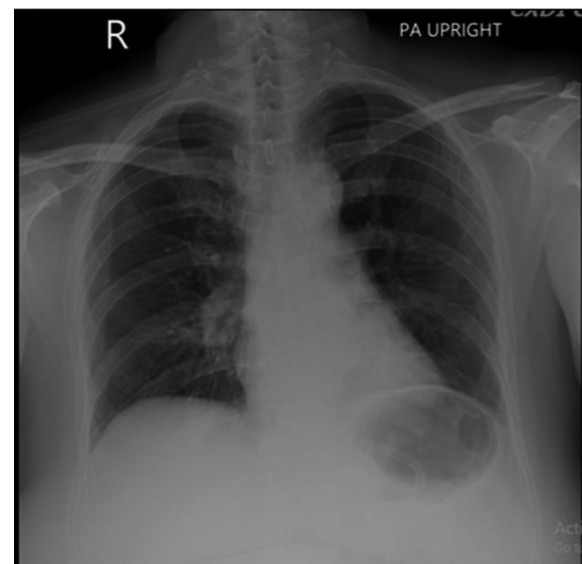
The chest radiography revealed improved lung fields, a response to treatment and resolved pneumonia.
